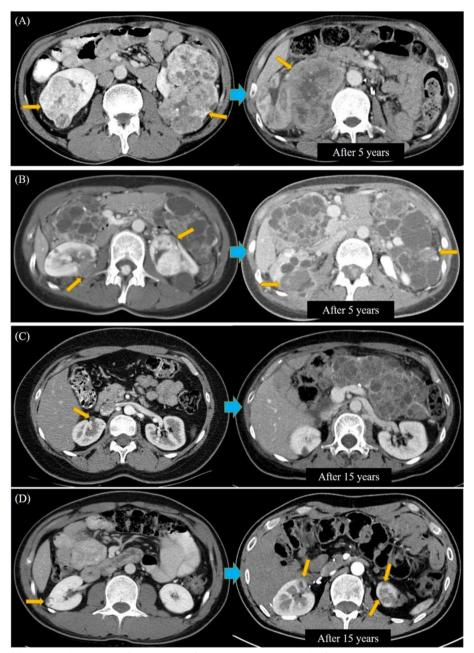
Baseline and follow-up axial CT images of two patients of the same age and sex, both of whom had a missense mutation but different RCC volumes at baseline. A left A male patient in his early 40 s with large RCCs (~6.1 cm) in both kidneys. A right The patient underwent left radical nephrectomy and right partial nephrectomy, and the 5-year follow-up CT scan shows a large recurrent RCC (4.9 cm) in the mid pole of the right kidney. B left Another male patient of the same age with small RCCs (~2.0 cm) in both kidneys. B right A 5-year follow-up CT scan shows relatively small increase in the size of the RCCs (~3.8 cm) in both kidneys. C left. Baseline axial CT image of a female patient in her 40 s with a small RCC (0.5 cm) in the upper pole of the right kidney. She underwent tumorectomy and (C, right) a 15-year follow-up axial CT scan shows no recurrence.
